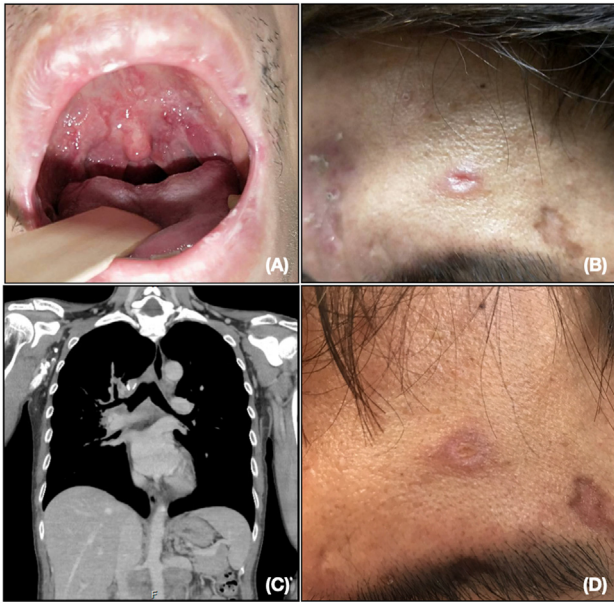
Physical examination findings in our patient with disseminated talaromycosis included painful oral ulcers (1A) and papules with central umbilication over his face (1B). The selected cut of CT scan showed mediastinal and paraaortic lymphadenopathies (1C). After one-week of liposomal amphotericin B treatment, the facial lesions resolved (1D).
